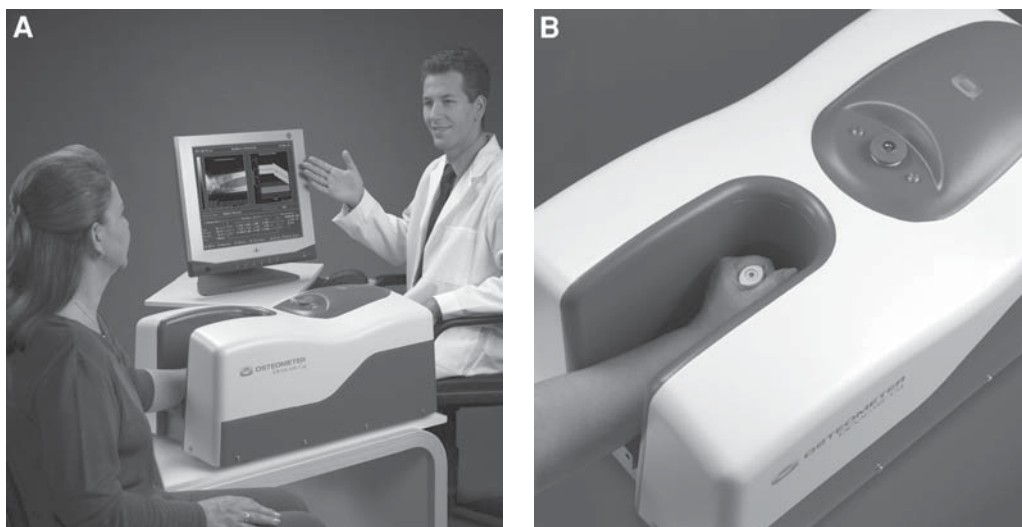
(A) The Osteometer DEXACare® G4. A peripheral dual energy X-ray absorptiometer used to measure bone density in the forearm. (B) The forearm is placed into the well on the top of the machine. Photographs courtesy of Osteometer MediTech, Hawthorne, CA.
